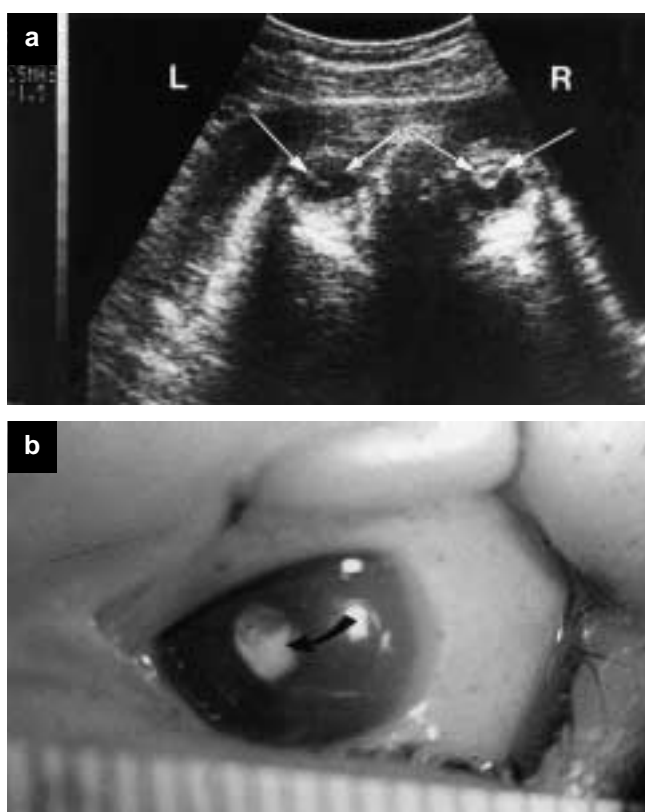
(a) Ultrasound image showing a transverse section of the fetal head at the level of the orbits. Note the hyperechogenicity of the right (R) lens (right arrows), when compared to the normal left (L) lens (left arrows). (b) Postnatal detail of the right lens showing the cataract (curved arrow)
